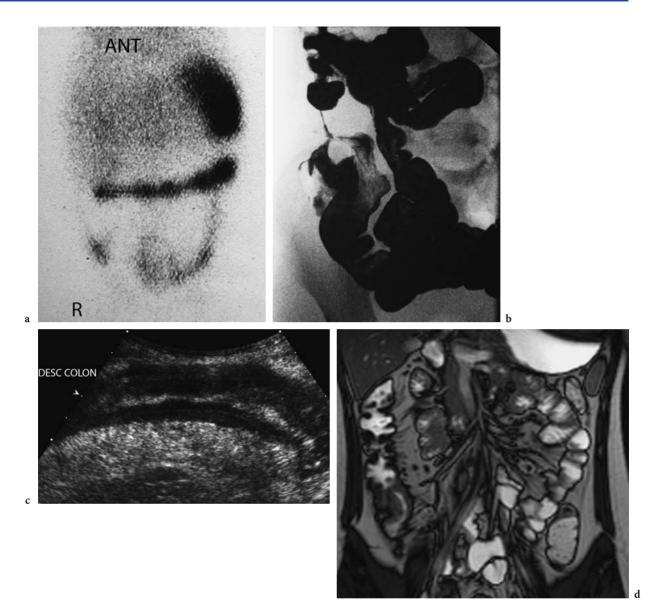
Crohn's disease of the colon. a Indium labelled white cell scan in active disease with widespread involvement of the caecum, transverse and descending colon. b Barium follow through demonstrating stricture formation of the ascending colon with displaced adjacent bowel consistent with an inflammatory mass. c Ultrasound of the descending colon in a patient with active disease. Note the thickened bowel wall and the obliterated bowel lumen. d Coronal MRI showing marked wall thickening of the caecal pole with a narrowed lumen
